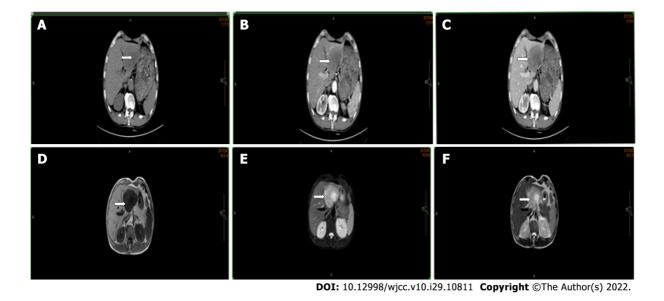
Abdominal computed tomography scan and magnetic resonance imaging show a tumor in the left lateral lobe (arrow). A: No contrast phase; B: Hepatic arterial phase; C: Portal venous phase; D: T1; E: T2 weighted-turbo spin echo; F: T2.
